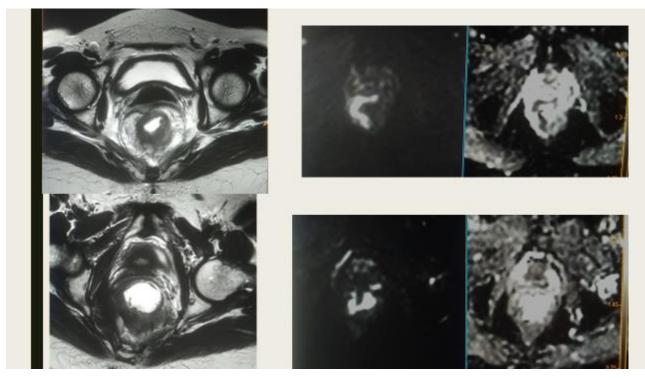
Comparison of MRI treatment response categories between long and short course neoadjuvant CRT56 year old male with mid-level circumferential disease who then underwent short course treatment. The patient had overall signs of poor response but a 50% increase in the ADC values was noted in the post treatment MR images.
